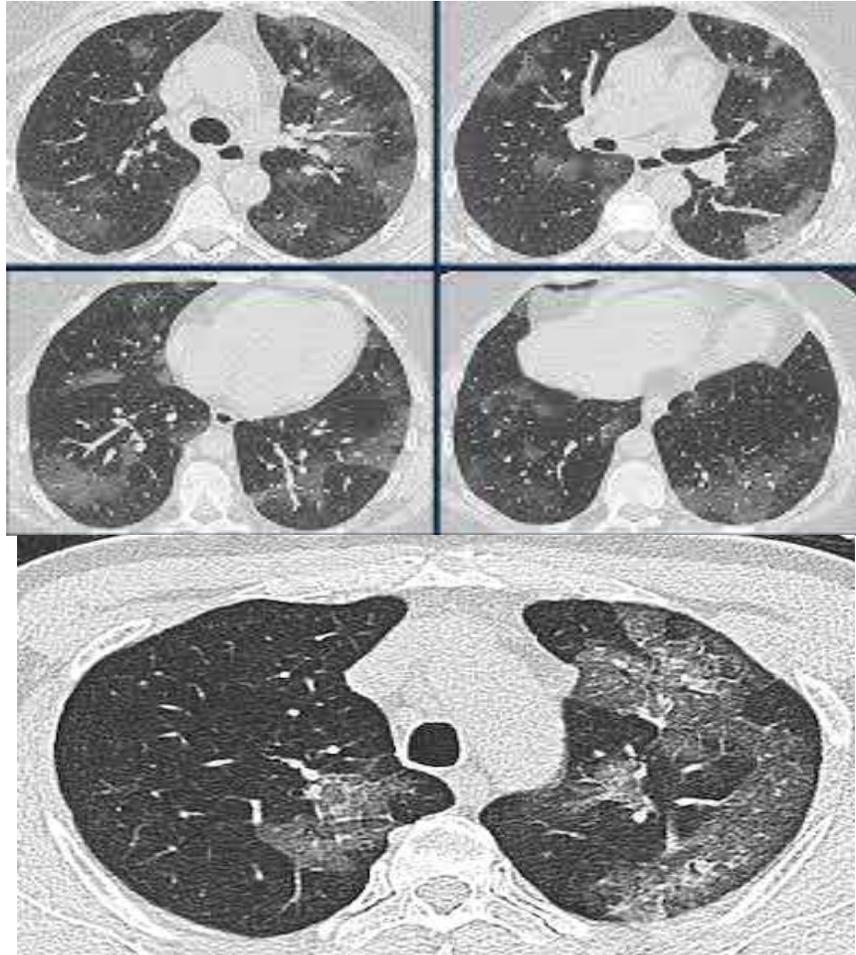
Ground glass opacity in lung field axial CT Scan Image.
